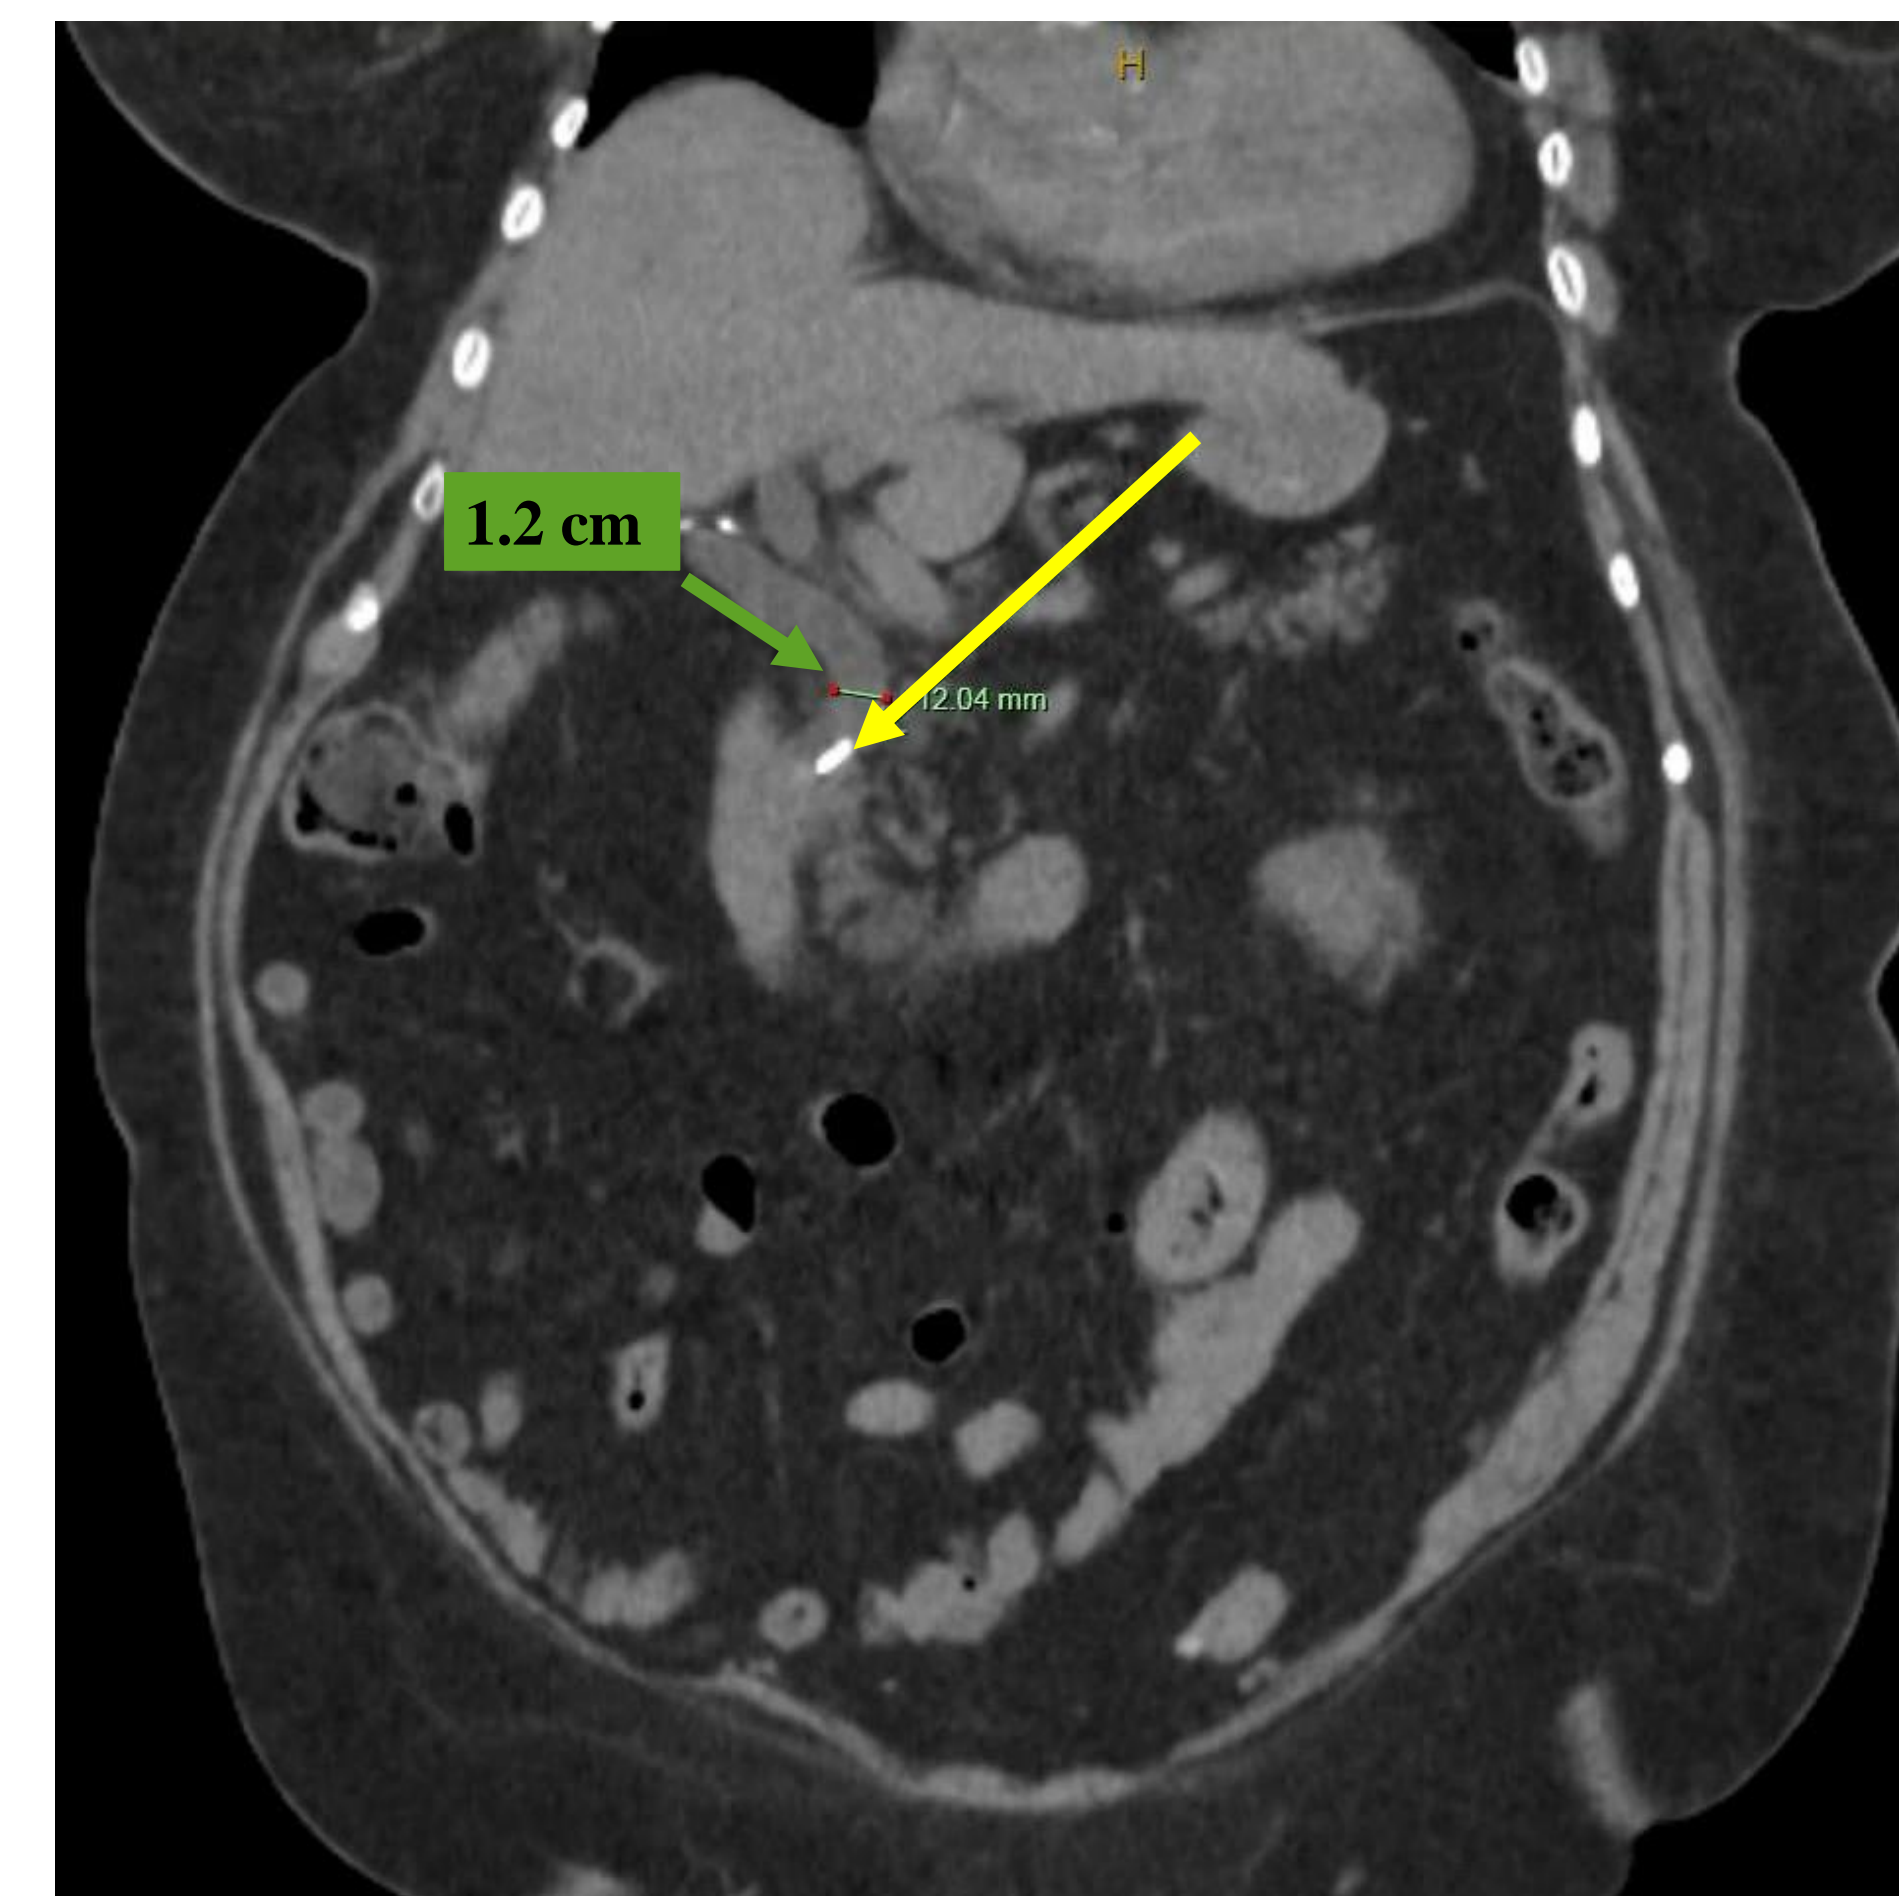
Abdominopelvic CT scan without contrast. Yellow arrow shows surgical clip within the common bile duct causing the obstruction. Green arrow shows the common bile duct with a 1.2 cm duct dilation.
